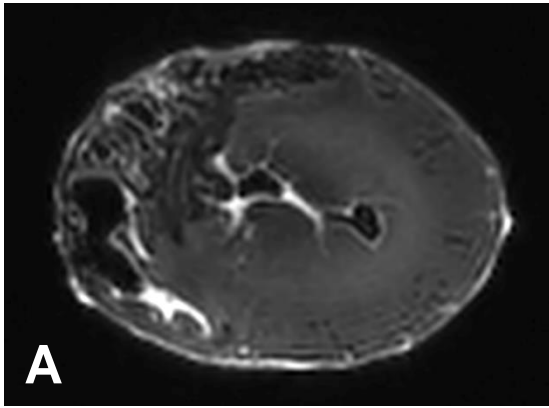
Mid-ventricular T2-weighted MR scans of excised hearts approximately 48 hours after myocardial infarction and cardiac arrest. A) short-axis, B) long-axis, and C) short-axis with measurements of left ventricular size (in green), left ventricular lumen including papillary muscles (in yellow), and infarct area (in orange).
